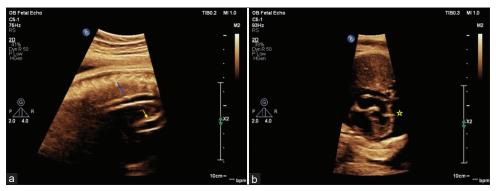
Fetal echocardiography (a) Aortic arch view showing the hyperechoic ascending aorta (yellow arrow), transverse arch, and descending thoracic aorta (blue arrow) (b) Four-chamber view showing large pericardial effusion (*)
